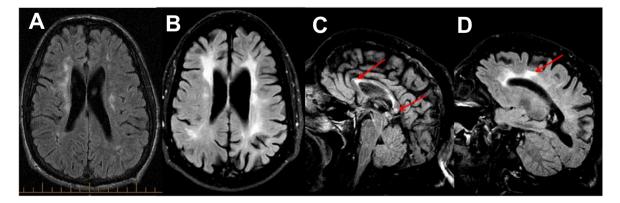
Axial FLAIR images of (A) Case 1 and (B) Case 2 reveal confluent periventricular and deep white matter lesions, with diffuse cerebral atrophy most prominent in Case 2. Sagittal FLAIR images of Case 2 show (C) notable atrophy of the corpus callosum and increased signal intensity particularly at the genu and splenium and (D) periventricular T2 hyperintensities most prominent within the frontal lobes. Subcortical U-fibers are spared and no enhancement is seen post-gadolinium.
